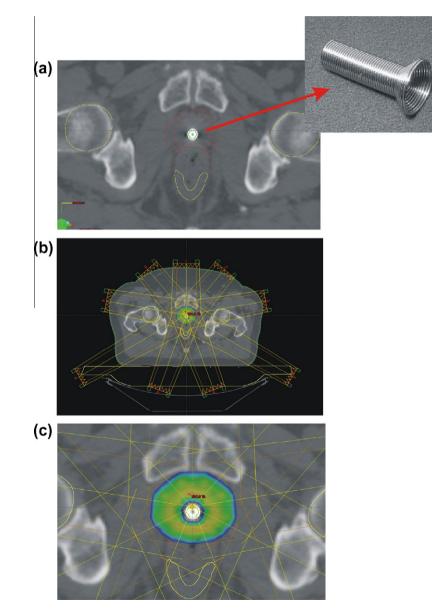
Delineation of the stent on the CT scan and IMRT planning. (a) Due to partial volume effects the true size of the stent is smaller than the appearance on the scan. The known physical size was used to correct for this effect (b) the 9-field treatment geometry (c) a urethra sparing dose distribution. The coloured regions indicate areas covered by more than 95% of the prescribed dose.
